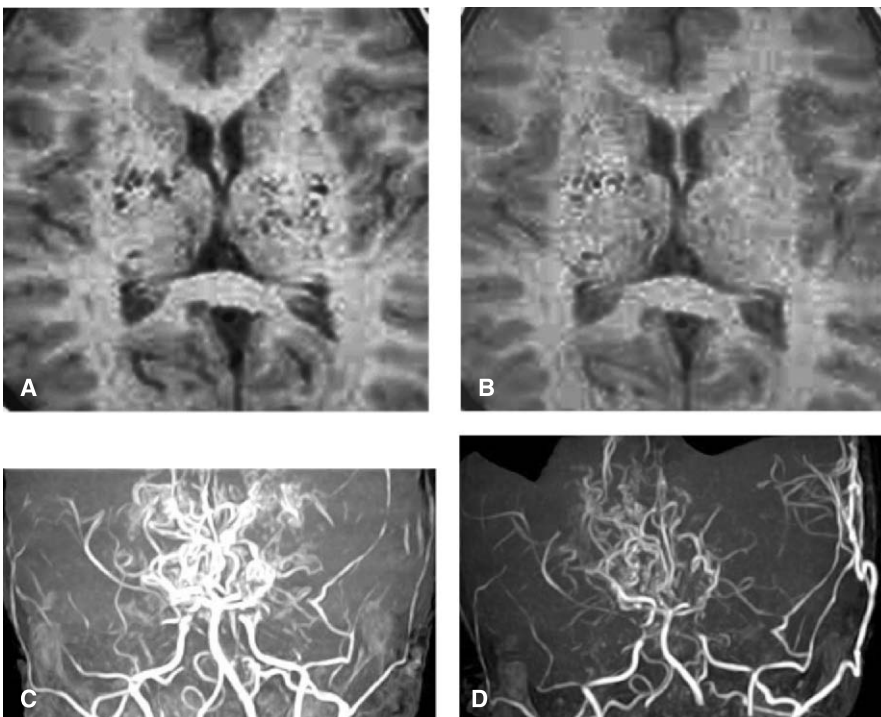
A 7-year-old boy who presented with bilateral transient ischemic attacks. (A) Preoperative T1-weighted MRI scan demonstrating multiple flow-voids at the bilateral basal ganglia. (B) T1-weighted MRI performed after left-sided STA-MCA anastomosis shows disappearance of the flow-voids in the left basal ganglia. (C) Preoperative MRA demonstrating bilateral stenosis of the internal carotid arteries and well-developed collateral vessels (basal Moyamoya vessels). (D) MRA obtained after left-sided STA-MCA anastomosis shows development of collateral flow through the bypass. The basal Moyamoya vessels on the left side appear faint
